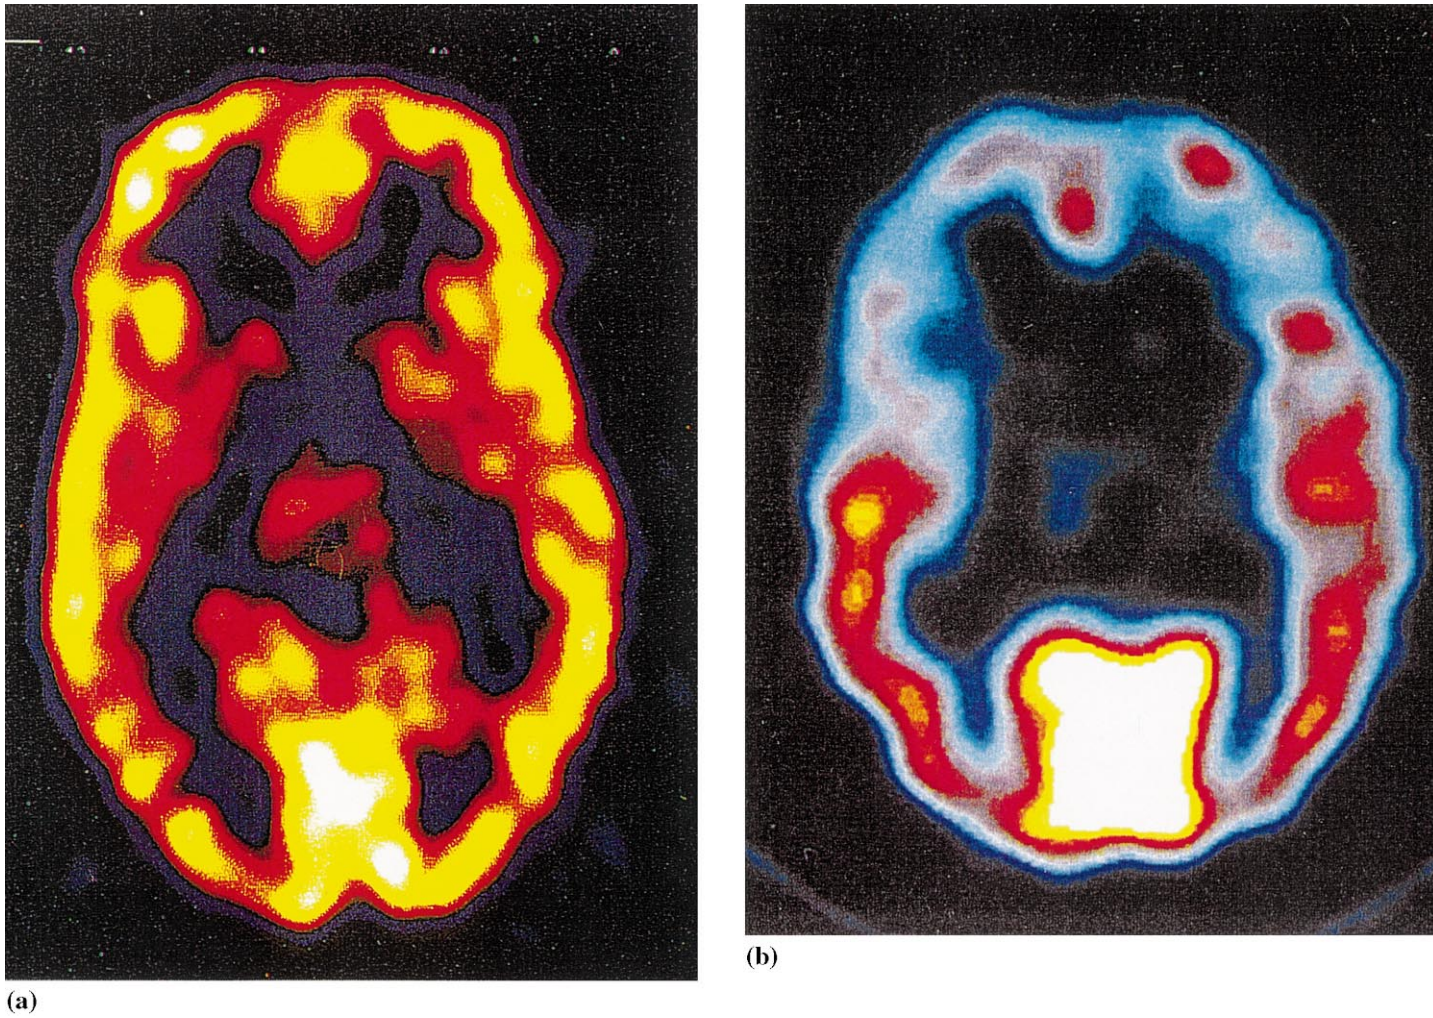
Axial images of radioligand distribution for PET [^{11}C]iomazenil (a) and SPECT [^{123}I]iomazenil (b) in a healthy human subject. Better resolution is visually appreciable in the PET vs. SPECT scan.
